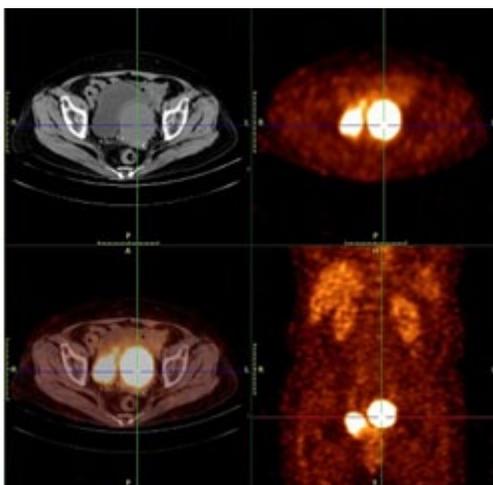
PET/CT results of the patient
